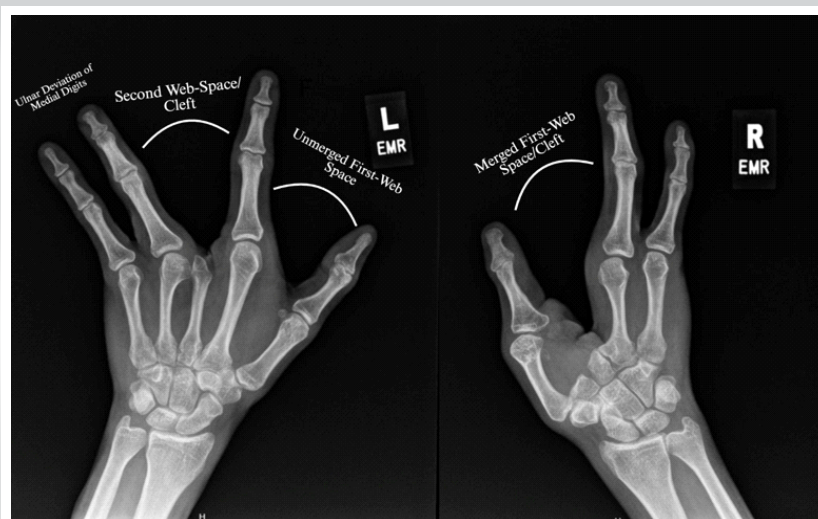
Bilateral merged hand X-rays demonstrating different cleft depth and difference in unmerged and merged phenotype.
